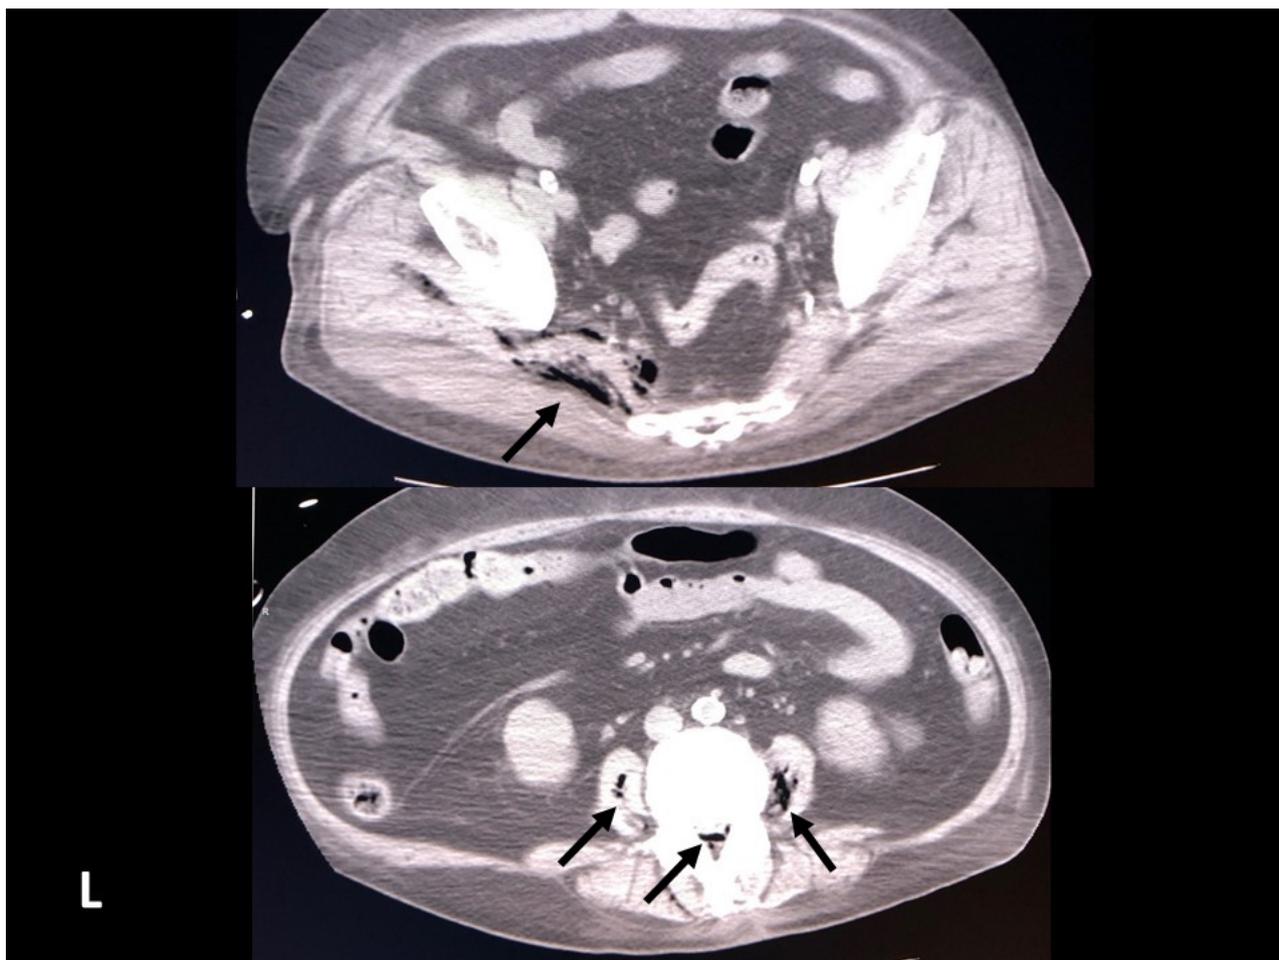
Truncal computed tomography on arrival. CT showed gas in the left deep buttock, spinal canal, and bilateral psoas muscle (arrow)
